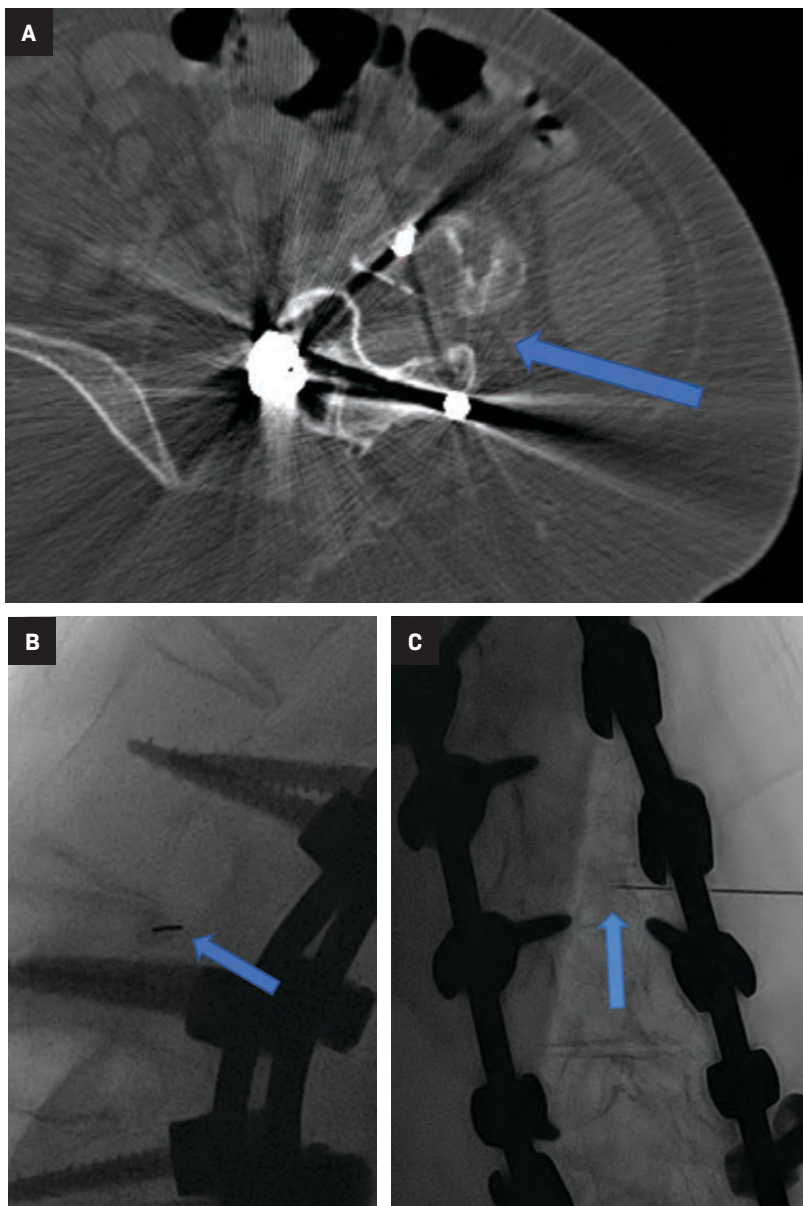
(A) CT axial image of the lumbar spine demonstrating planned left transforaminal access (blue arrow) for intrathecal nusinersen administration. (B) Lateral fluoroscopic view of the lumbar spine with the spinal needle (blue arrow) entering the inferior-most aspect of the neural foramen to avoid the neurovascular structures typically traversing the upper 2/3 of the foramen. (C) Frontal fluoroscopic image demonstrating the spinal needle tip (blue arrow) near the midline of the thecal sac.
